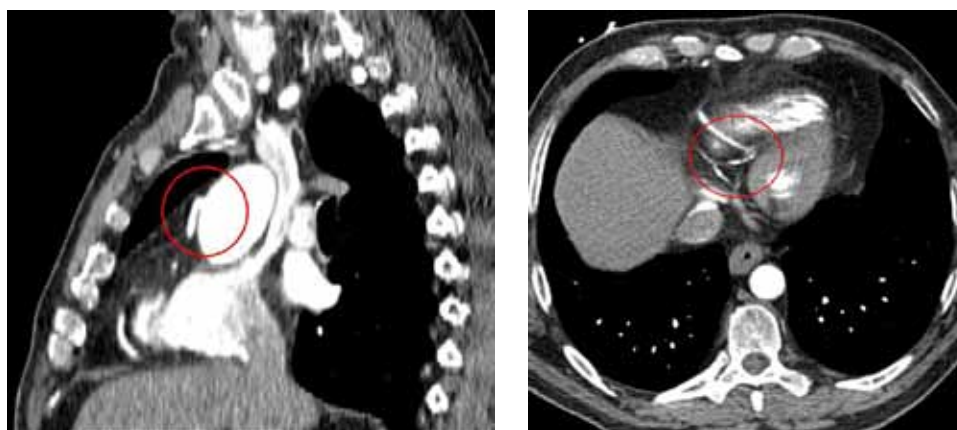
CT scans of individual aorto-coronary bypass model – position of the proximal end-to-side anastomosis (*left*) and the distal end-to-side anastomosis (*right*)
